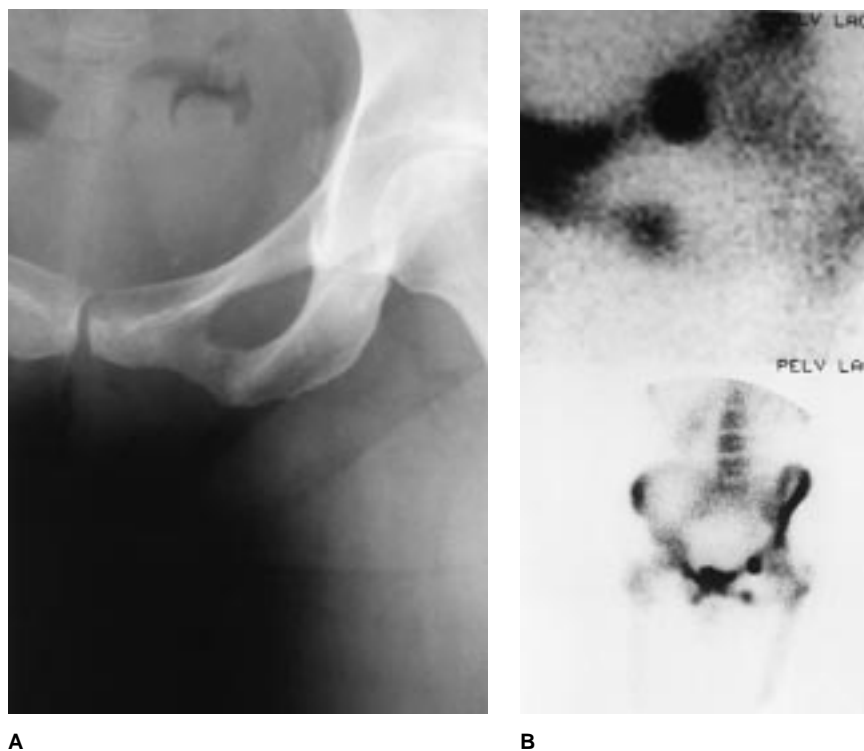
A, Radiograph shows a stress fracture in the inferior pubic ramus. B, Bone scan reveals the stress fracture seen on the radiograph as well as an additional fracture in the superior pubic ramus.
